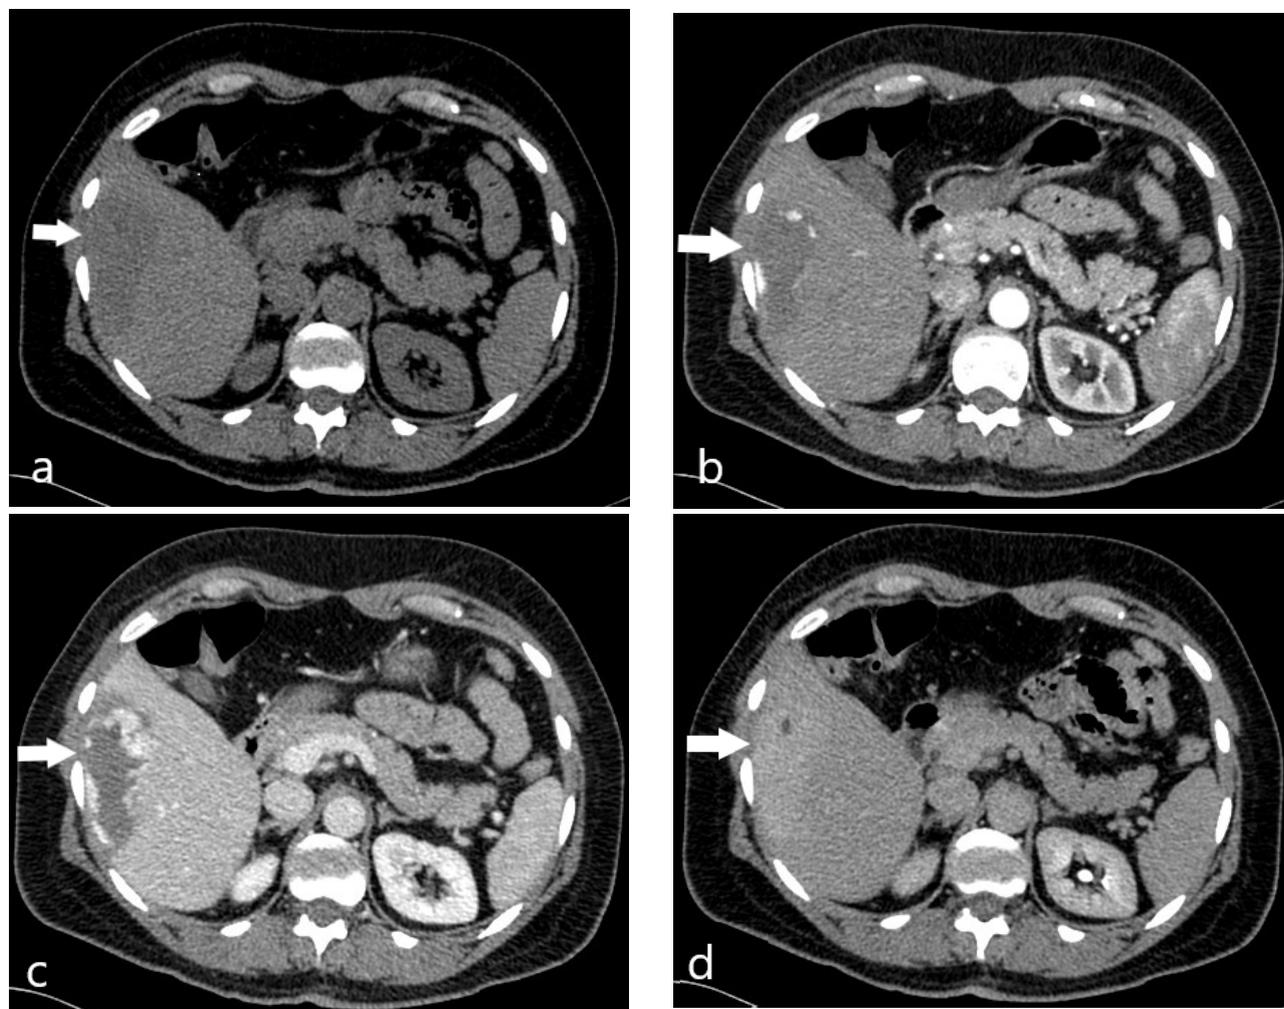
(a) Axial unenhanced CT image shows a well-defined lesion (arrow) in the right liver lobe. The mass appears mainly hypodense, when compared to normal liver parenchyma. (b) Axial contrast-enhanced CT image in the arterial phase shows discontinuous, nodular areas of enhancement in the periphery of the lesion (arrow), almost isodense to the aorta. (c) Portal phase demonstrates progressive peripheral enhancement with more centripetal fill-in (arrow). (d) Delayed phase shows nearly complete fill-in. The lesion (arrow) appears mainly slightly hyperdense compared to the surrounding liver.
